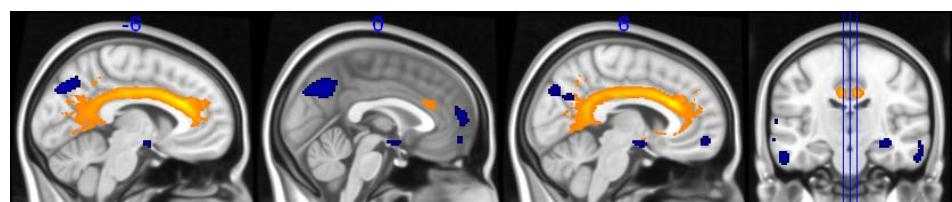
Areas of reduced GM volume in AD patients (blue), and mean cingulum bundles reconstructed by DT MRI tractography (orange).
